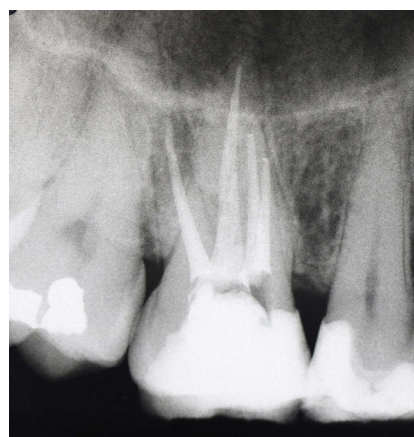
Postoperative radiograph of the right permanent maxillary first molar.
